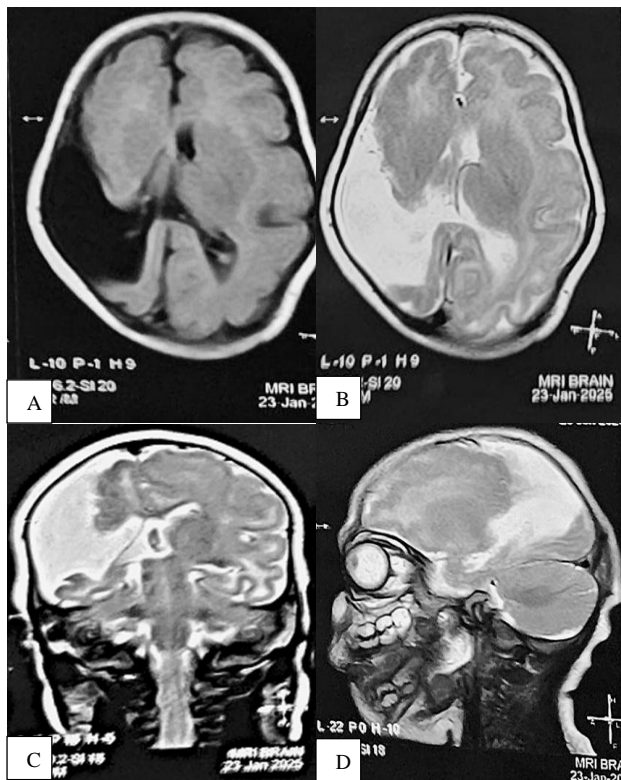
(A-D): MRI brain suggestive of open-lip schizencephaly.
